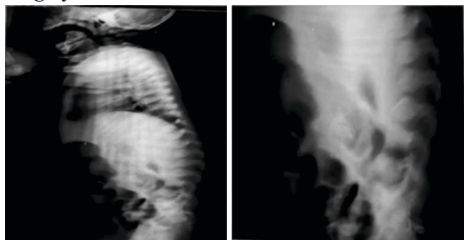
Lateral radiograph of D-L spine and magnified image of Lower lumbar vertebrae showing Anterior spinal beaking.
